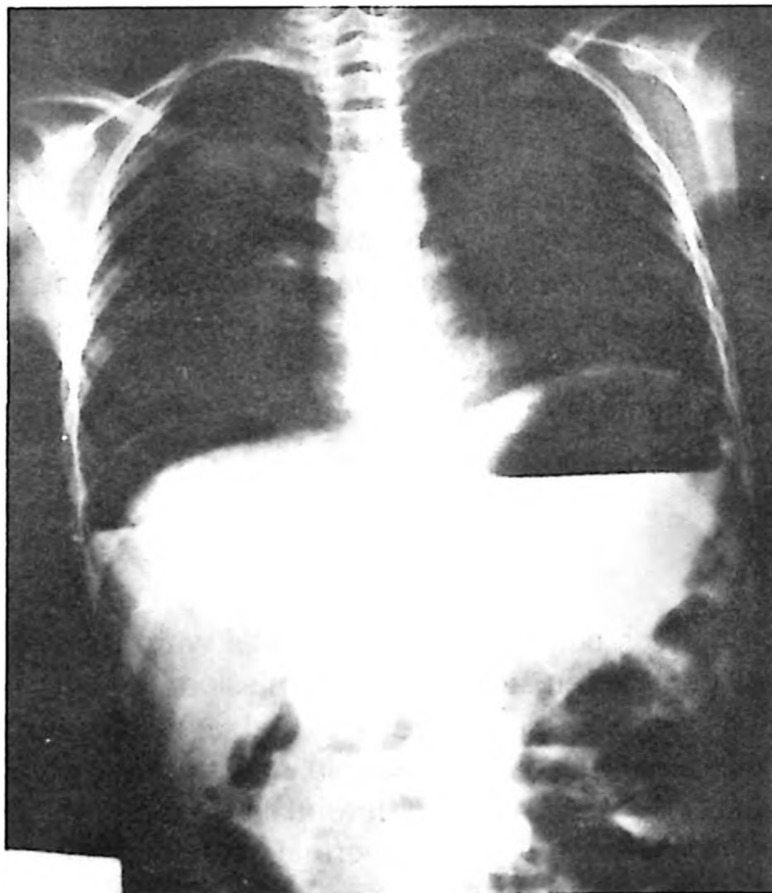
Abdominal x-ray showing free air under the diaphragm.
